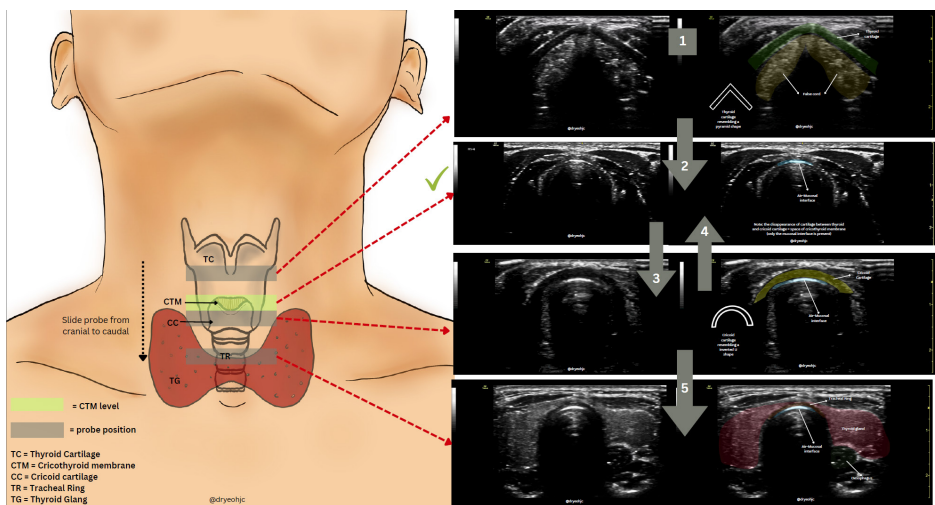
The transverse approach of airway ultrasound. (1) Identify the thyroid cartilage (resembles a pyramid shape). (2) Slide down caudally until the thyroid cartilage disappears from sight, leaving the air mucosal interface alone. (3) Slide further down to view the cricoid cartilage (resembles an inverted U shape). (4) Slide cranially to visualise the space between the thyroid and cricoid cartilage, *i.e.*, cricothyroid membrane space. (5) Slide caudally to visualise the tracheal rings. The thyroid gland will appear as the probe moves more caudally to the sternal notch.
